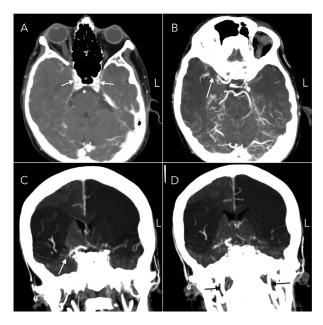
Brain CT angiogram. A) Axial view, both internal carotid arteries show contrast filling in the cavernous segment (arrows). B) A higher view shows occlusion of the right middle cerebral artery (arrow), the left middle cerebral artery is not observed. Note the normal anatomy of the basilar artery bifurcation. C) Coronal view, bifurcation of the right carotid artery is observed showing adequate filling of the anterior cerebral artery; however, the middle cerebral artery shows a very important narrowing (arrow). The left carotid artery and its bifurcation are not visible. D) Both internal carotid arteries show a normal size before entering the intracranial compartment (arrows).
